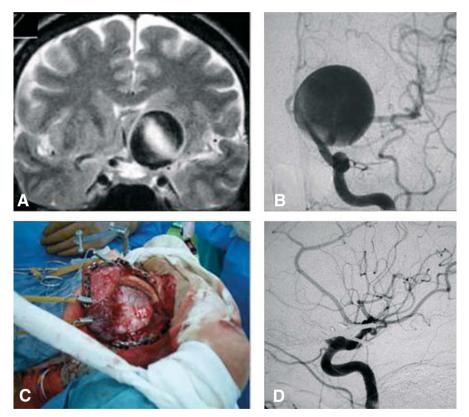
ICA aneurysm clipped under temporary bypass with radial artery graft (A coronal MRI image; B preoperative anterior-posterior view of the left carotid angiogram). After exposure of M2, the patient's arm was raised (C) and a radial artery-M2 end to side anastomosis was made. The ICA was then trapped between the ophthalmic artery and the anterior choroidal artery, while the radial artery-M2 bypass was kept open. The aneurysm was then punctured and clipped with straight and ring clips (D postoperative lateral view of the left carotid angiogram). The bypass was closed: The radial artery was re-positioned to its original site at the wrist. Postoperative course was uneventful
